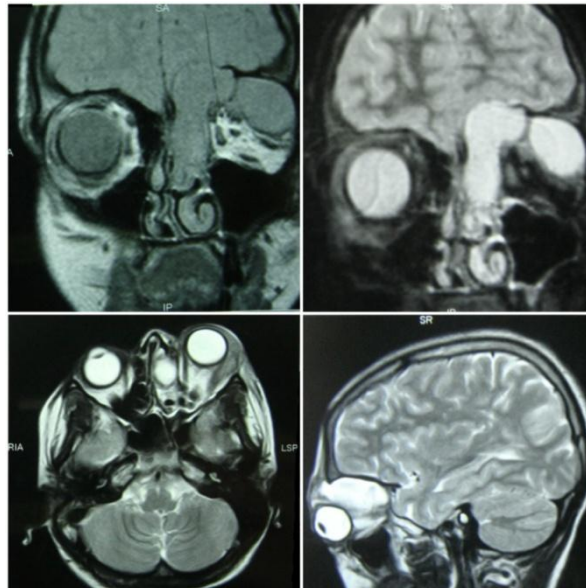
MRI Orbit suggestive of a bi-loculated lesion which is iso-hypointense on T1W images and hyperintense on T2W images with characteristic rim enhancement on post-contrast study. The mass is seen eroding the superomedial wall of the left orbit displacing the eyeball laterally and downwards, and extending to anterior cranial fossa
